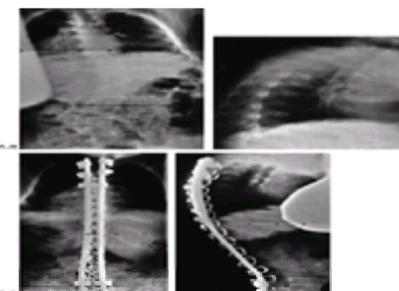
Treatment of scoliosis by posterior spinal fusion with segmental instrumentation, using mostly sublaminar wires. A two-level, transverse process, pedicle claw was used at the cephalad end in an attempt to prevent junctional kyphosis. A: Preoperative posteroanterior radiograph demonstrates a 45-degree lumbar curve. B: Preoperative lateral radiograph demonstrates associated thoracic kyphosis. C: Postoperative posteroanterior radiograph. D: Postoperative lateral radiograph demonstrates the cephalad claw configuration of the hooks.
